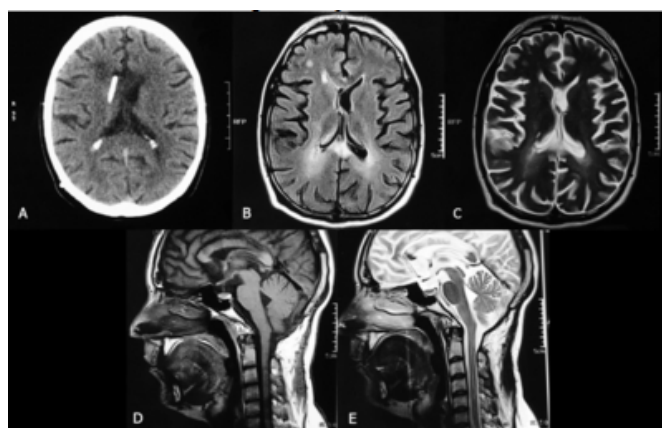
(A) Postoperative CT scan depicting correct position of the catheter tip. Axial T1- (B) and T2- (C) weighted as well as coronal (D) and sagittal (E) T1-weighted MRIs showing regression of hydrocephalus and brainstem compression
